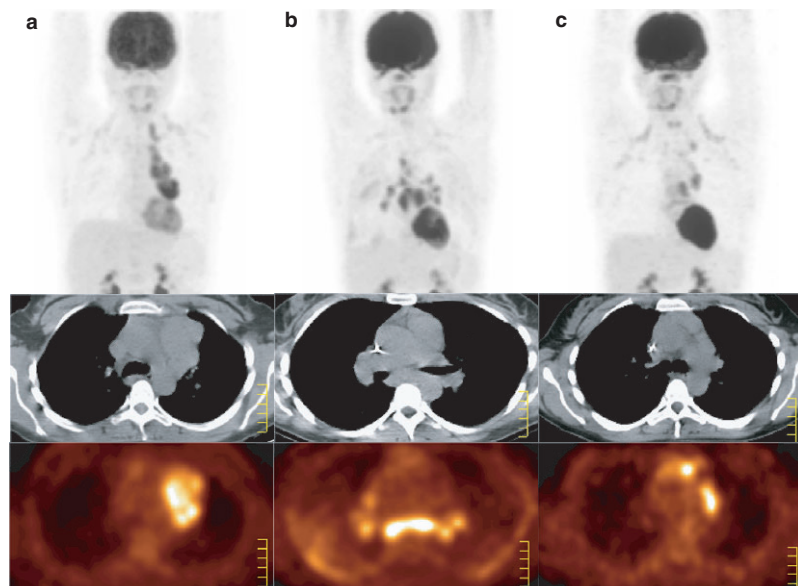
A 31-year-old patient presented with Hodgkin's lymphoma. (a, left column) Baseline PET/CT shows left anterior mediastinal mass with associated lymph nodes over left lower neck. (b, middle column) PET/CT at the end of treatment demonstrates abnormal FDG uptake, mainly in the subcarinal and bilateral hilar areas, which was proven by mediastinoscopic lymph node biopsy to be related to sarcoidosis instead of disease progression. (c, right column) PET/CT performed 6 months later, lymphoma relapse over the anterior mediastinum is noted while the activity of sarcoidosis regresses. Note: faint bilateral neck and axillary uptake corresponds to physiologic brown fat activity.
